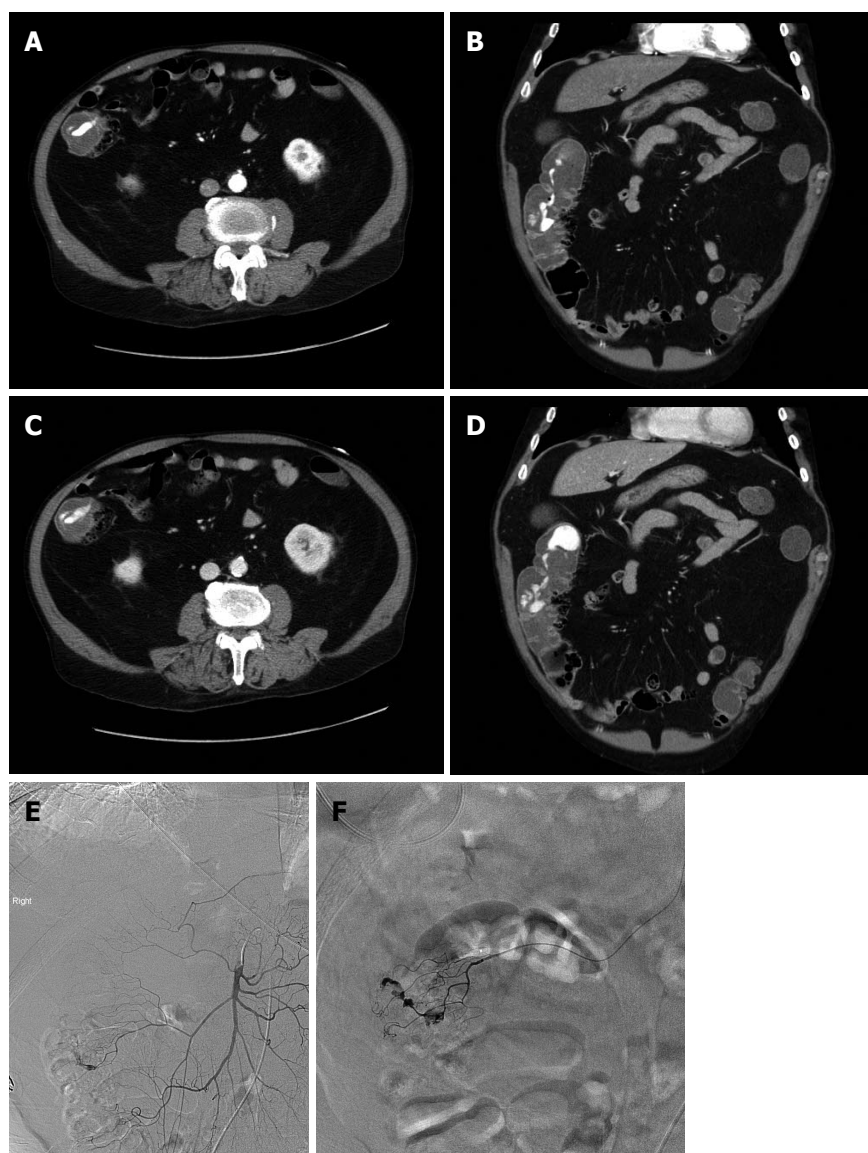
73-year-old man with per rectal bleeding and active gastrointestinal hemorrhage. Contrast enhanced computed tomography (CT) angiogram images show extravasation of contrast into the lumen of the ascending colon, with pooling of contrast which increases from the arterial phase (A, B) to the delayed venous phase (C, D). Diverticula are seen arising from the medial wall of the ascending colon indicating the etiology of bleeding. Following the CT angiogram, the patient underwent catheter angiography, which demonstrated blush of contrast from the right colic branch of the superior mesenteric artery (E). Selective catheterization of the right colic artery demonstrates the bleeding focus more clearly (F). Gelfoam and coil embolization was subsequently performed.
